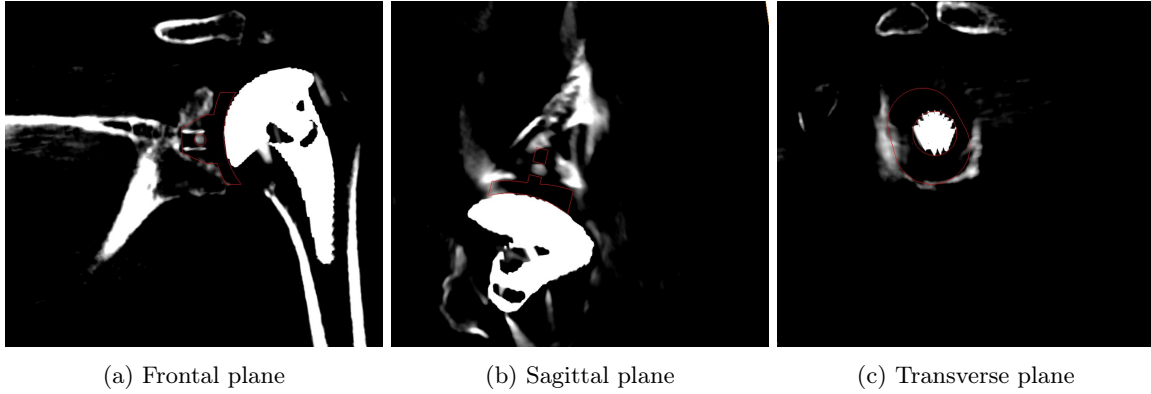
Positioning of the implant based on the postoperative CT-scans thanks to the principal planes
